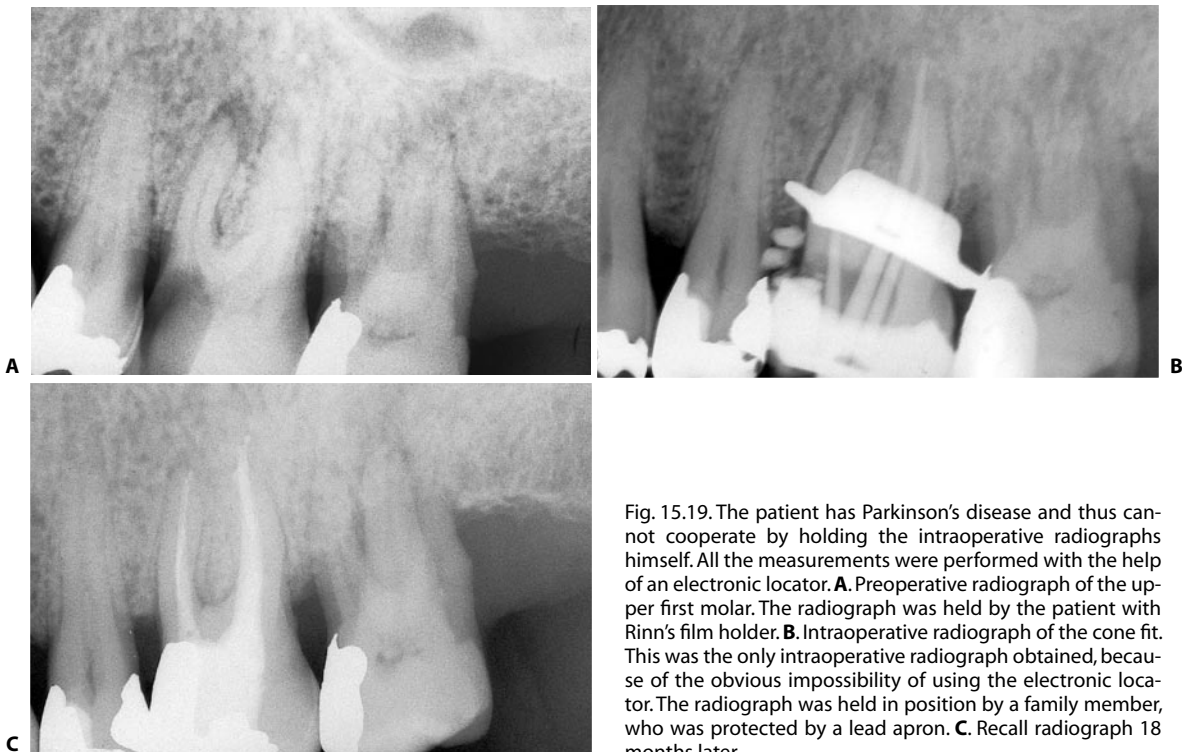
The patient has Parkinson's disease and thus cannot cooperate by holding the intraoperative radiographs himself. All the measurements were performed with the help of an electronic locator. A. Preoperative radiograph of the upper first molar. The radiograph was held by the patient with Rinn's film holder. B. Intraoperative radiograph of the cone fit. This was the only intraoperative radiograph obtained, because of the obvious impossibility of using the electronic locator. The radiograph was held in position by a family member, who was protected by a lead apron. C. Recall radiograph 18 months later.
